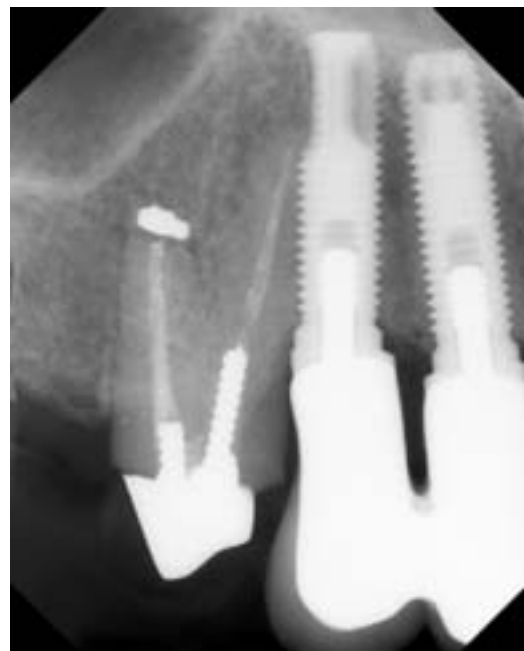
Preoperative radiograph showing the two restored osseointegrated implants.
